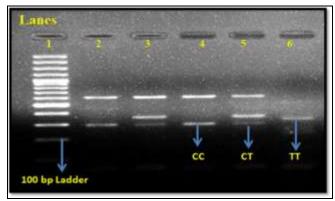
Electrophoretogram on 2% agarose gel showing amplified PCR products of TMPRSS2 gene polymorphism (rs12329760) showing CC, CT & TT genotype with DNA marker of 100 bp. Control band is at 600bp, CC genotype at 293bp and TT genotype at 353bp.Lane 1 represents Gene Ruler TM 100 bp ladder.Lanes 2 & 4 represent CC genotype. Lanes 3 & 5 represent CT genotype. Lane 6 represents TT genotype
